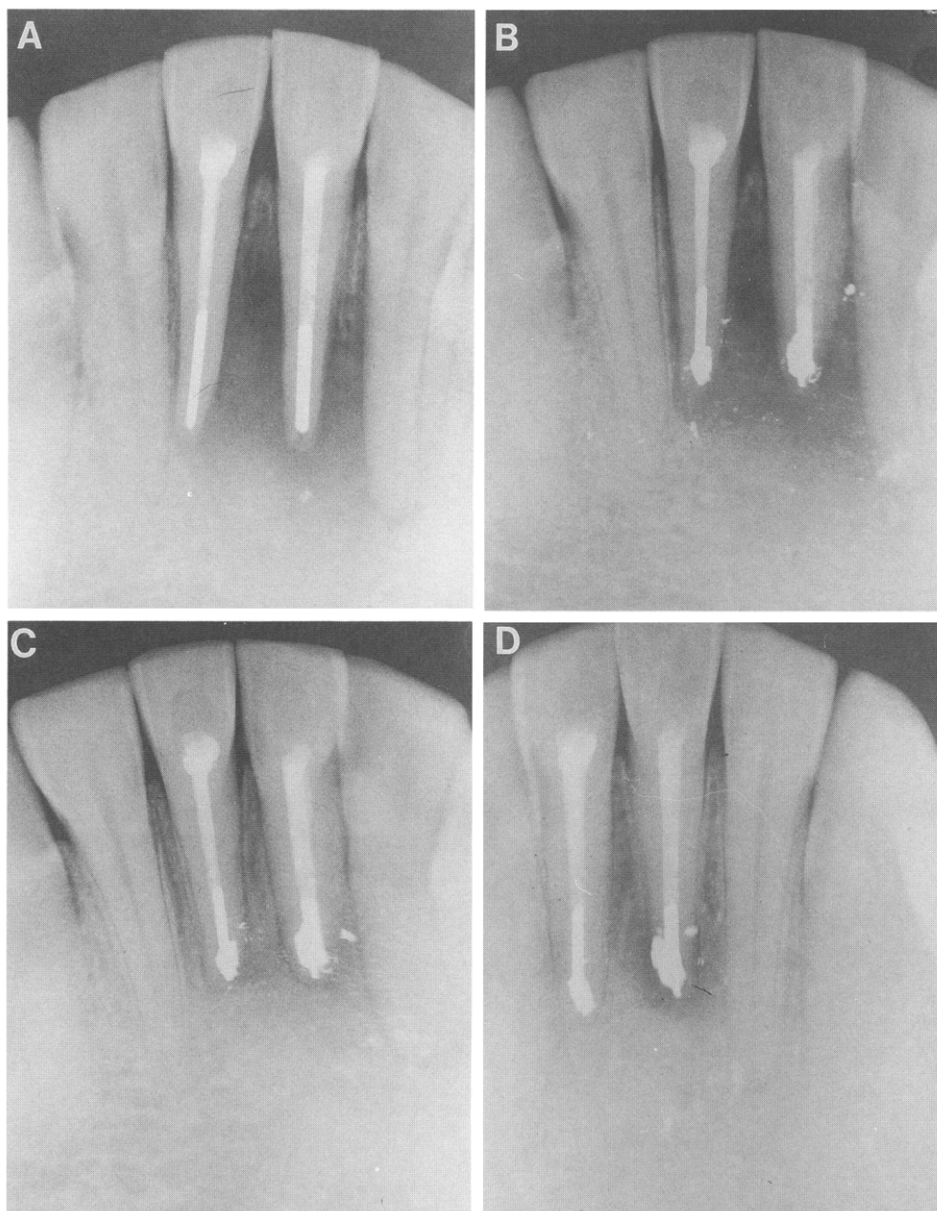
Case typical of this study. *A*, Preoperative view of mandibular central incisors, indicating large periapical lesions associated with teeth filled with sectioned silver points. *B*, Because of the difficulty involved in removing the silver points, apical surgery was performed. This film was taken after apicoectomies, curettage, and placement of apical amalgams. *C*, After 5 yr, periapical healing is complete for both roots. *D*, However, 6 yr later a radiolucency is present surrounding one apex and a sinus tract drains intermittently. The other tooth is still fine.
